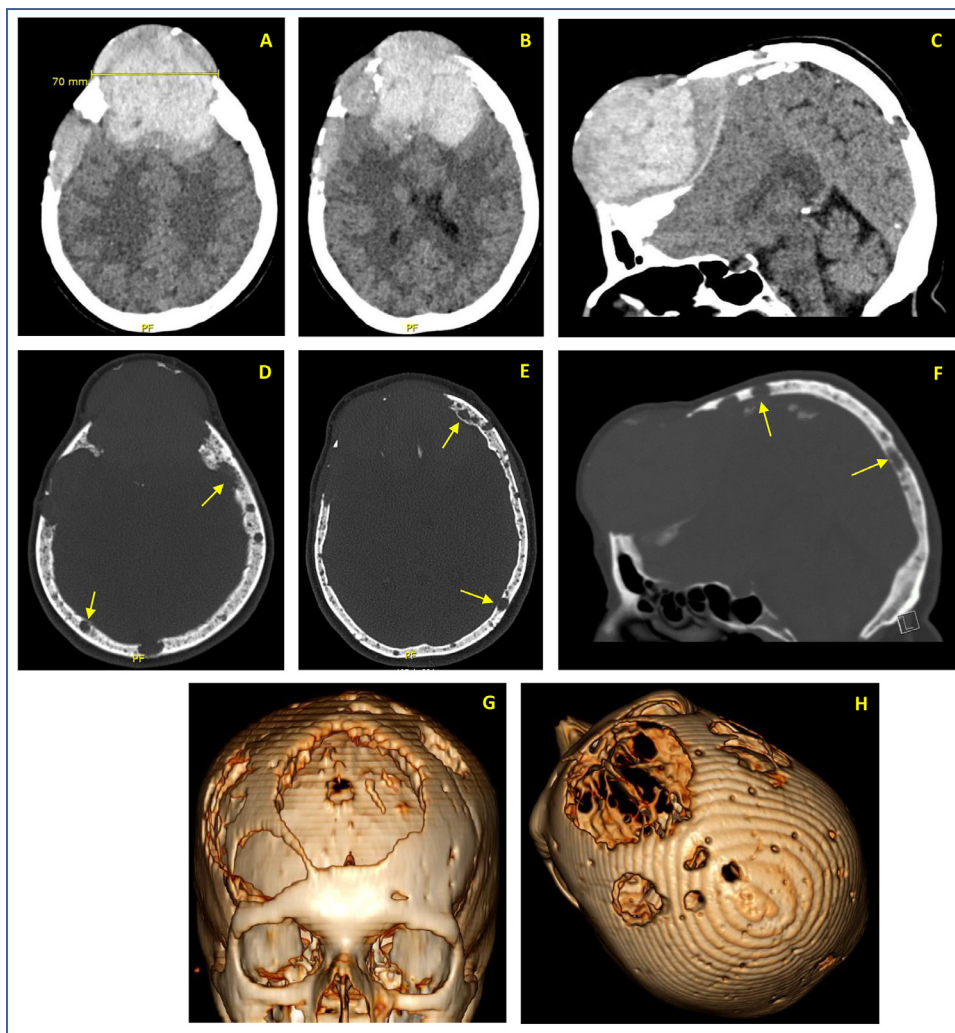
CT head axial and sagittal brain (A, B, C) and bone window (D, E, F) of a mass eroding the frontal bone with bony fragments (arrowhead) and lytic lesions in skull (arrows). 3D rebuilding from head CT series: frontal view with complete loss of frontal bone below the mass (G), upper view with multiple erosive bone areas corresponding with lytic bone lesions (H).
